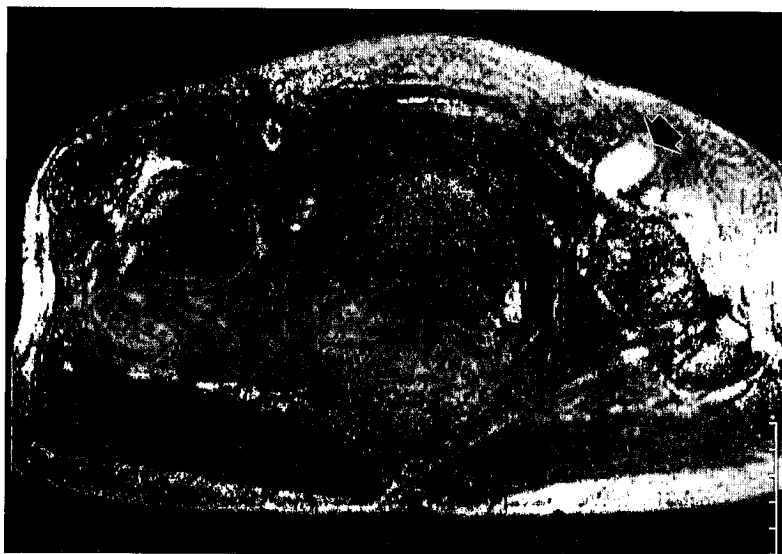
Axial T2 weighted MRI (2000/90) revealed the enlarged iliopsoas bursa at high intensity (arrow).
